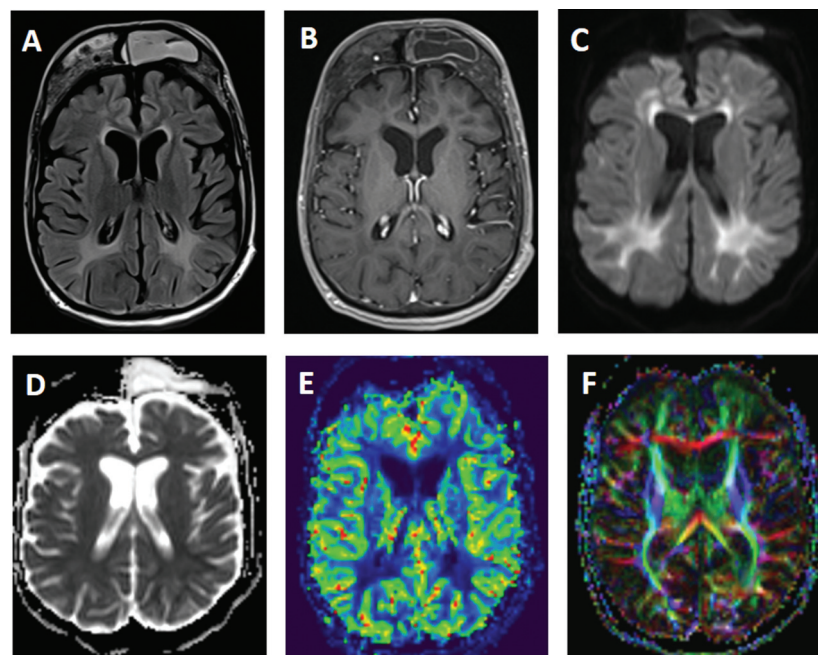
Axial fluid attenuation inversion recovery (A) MR image shows extensively increased periventricular white matter signal abnormalities in both cerebral hemispheres. No contrast-enhancing lesion is observed in post-contrast T1-weighted (B) MR imaging. Axial fluid attenuation inversion recovery and post-contrast T1-weighted MR images also demonstrate a prominent hyperostosis of the frontal bone. Diffusion weight imaging (C) shows bright signals in the periventricular white matter representing restricted diffusion with slightly hypointense ADC map (D). rCBF perfusion (E) MR reveals slightly hypoperfused white matter areas. Diffusion tensor imaging (F) shows thinning white matter fibers.
